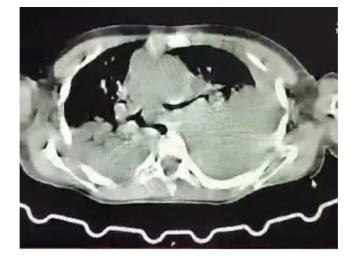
Bilateral pleural effusion and left lower lobe consolidation and collapse were obvious in the index chest CT scan of the patient.
